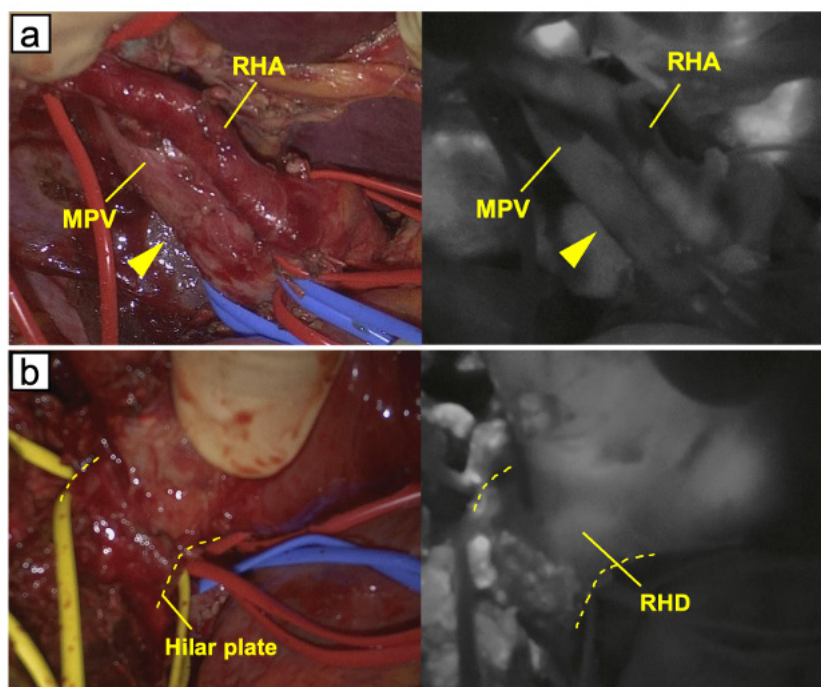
Indocyanine green fluorescence imaging performed to confirm vascular perfusion and visualize the bile duct. (a) Indocyanine green fluorescence imaging (ICG-FI) in Monochromatic display mode demonstrated uninterrupted fluorescence passage through right hepatic artery and reconstructed portal vein (yellow arrowhead) after wedge resection of main portal vein. Blood flow was assessed in combination with intraoperative Doppler ultrasonography. Following intravenous ICG injection, fluorescence was observed in right hepatic artery at 30 seconds and in reconstructed portal vein at 40 seconds, with uninterrupted passage through both vessels. (b) ICG-FI in Monochromatic display mode shows right hepatic duct within the hilar plate (dotted yellow line), visualized 95 minutes after intravenous injection of 2.5 mg of ICG. *Abbreviations:* RHA, right hepatic artery; MPV, main portal vein; RHD, right hepatic duct.
